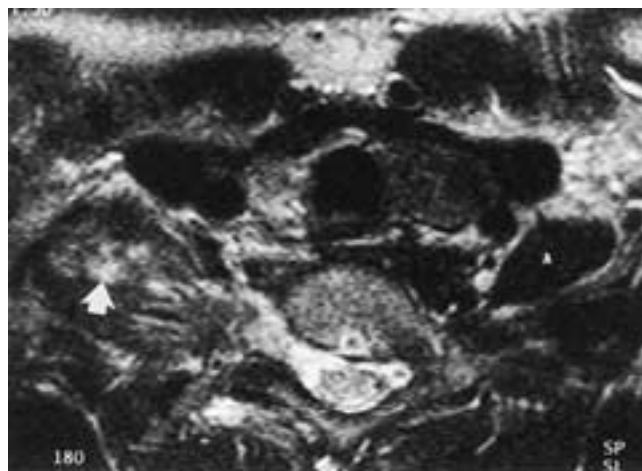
Soft-tissue injury of the anterior and middle scalene muscles. Axial T1-weighted MR image shows increased signal in the region of the right anterior scalene muscles (arrow). The normal anterior (A) scalene muscle is seen on the left. This patient had a normal CT scan and myelogram.
